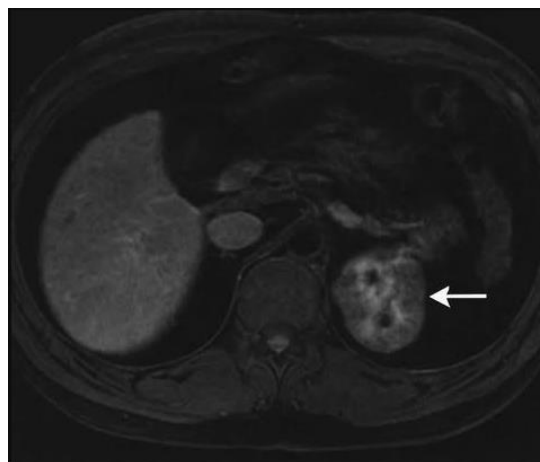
Axial MRI T2 SPIR scan showing chronic glomerulonephritis with renal cortical thinning and reduced corticomedullary differentiation
